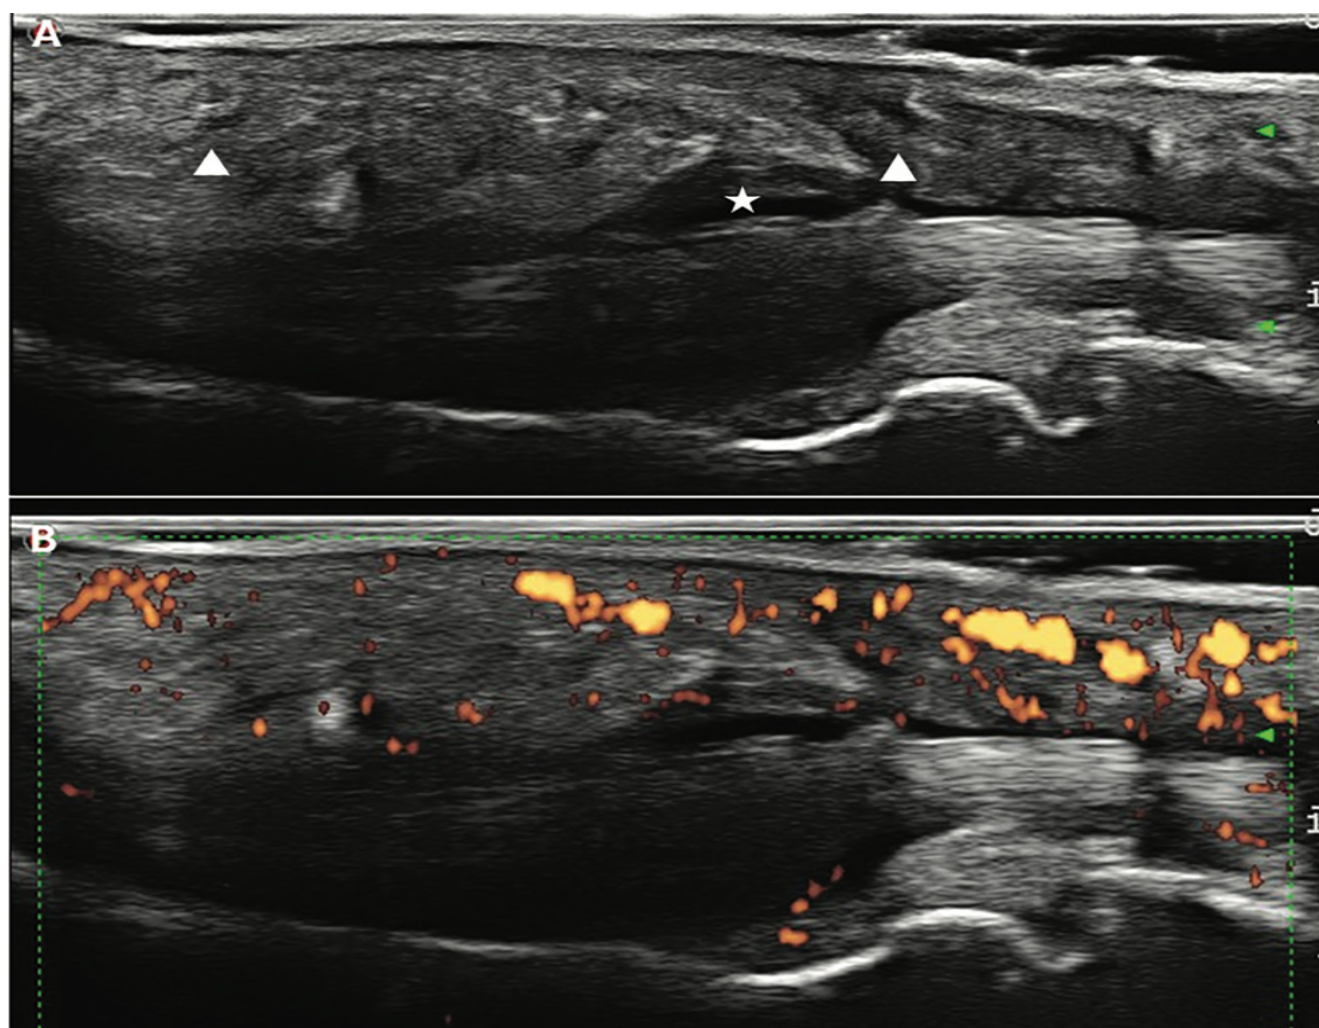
Longitudinal ultrasound assessment of early hand dactylitis in a psoriasis patient.
